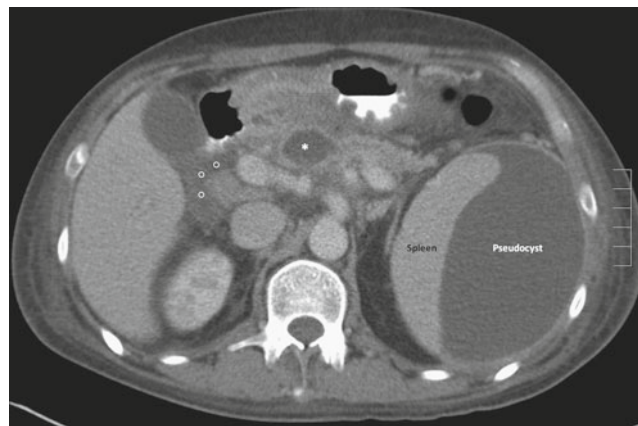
A 65-year-old man with LUQ abdominal pain. Axial oral and intravenous enhanced CT image through the upper abdomen shows subcapsular fluid collection in the spleen and a small fluid collection (*asterisk*) in the body of the pancreas with some inflammatory changes anteriorly. Small amount of fluid (*white circles*) is noted around the head of the pancreas. Diagnosis: Pancreatic pseudocyst
